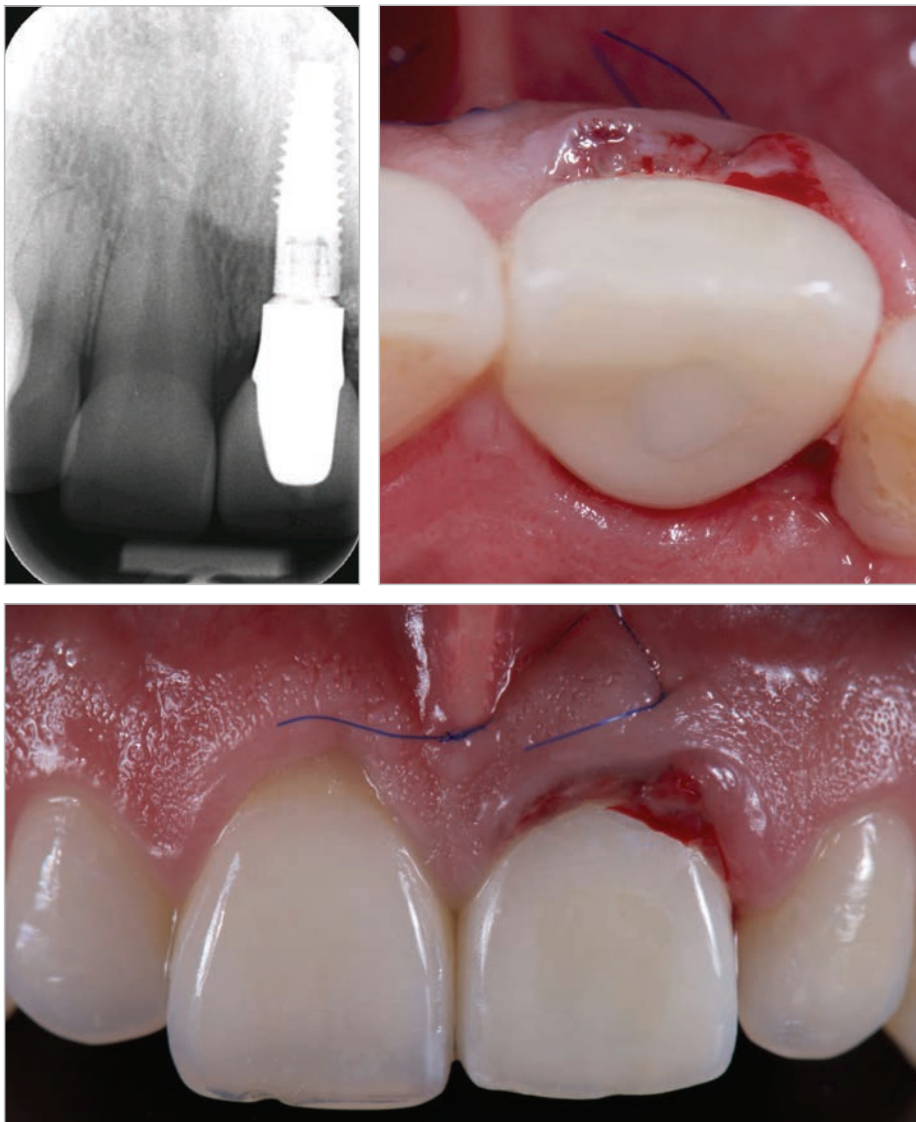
Post-operative radiograph and clinical images.
